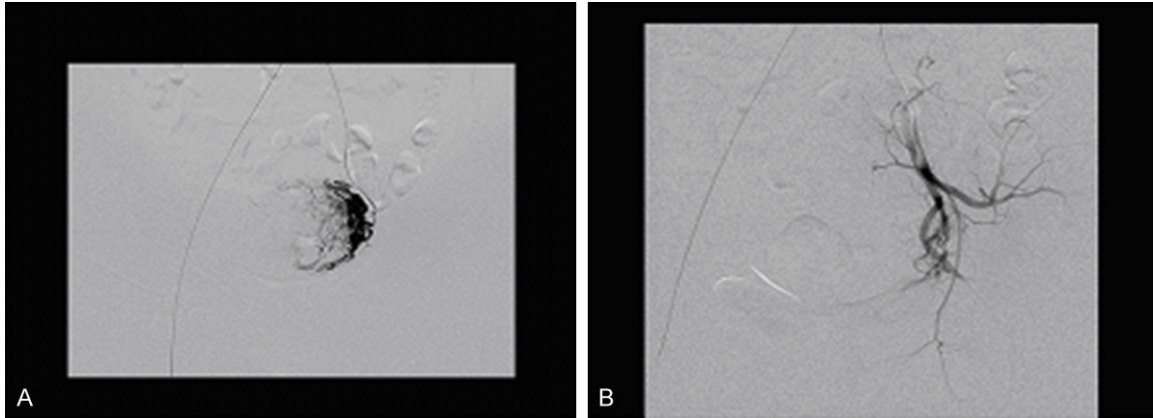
A. X-ray DSA of the uterine artery, arterial phase showed enlarging filling artery by absorbable genlatin sponge. B. After the embolization of uterine artery, x-ray DSA found uterine vascular shadow was dismissed.
